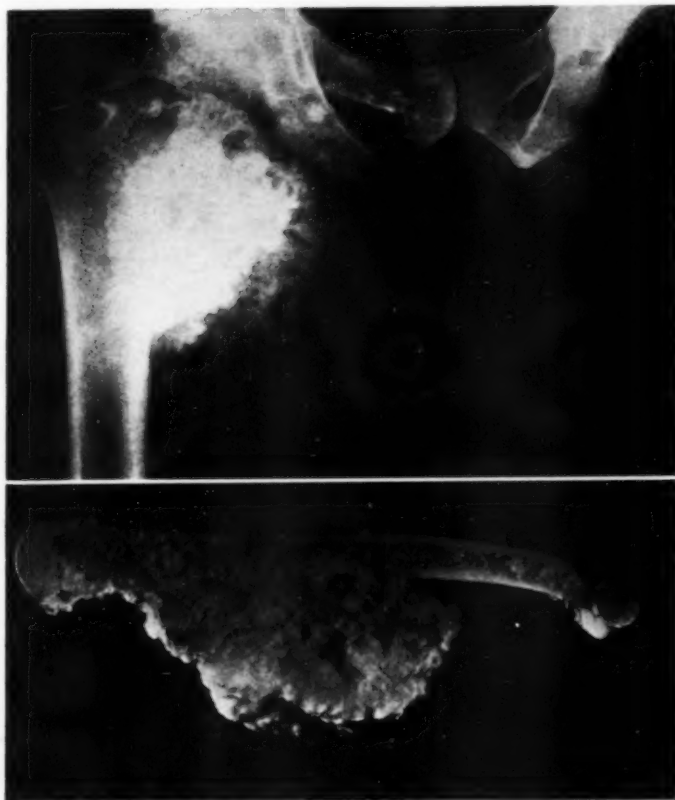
(above). Roentgenogram of a secondary chondrosarcoma developing in the cap of an osteochondroma of the lesser trochanter.
